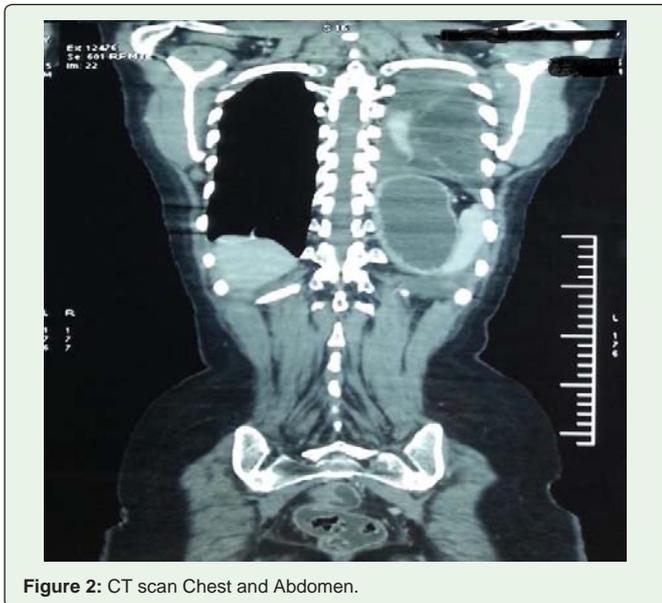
CT scan Chest and Abdomen.
